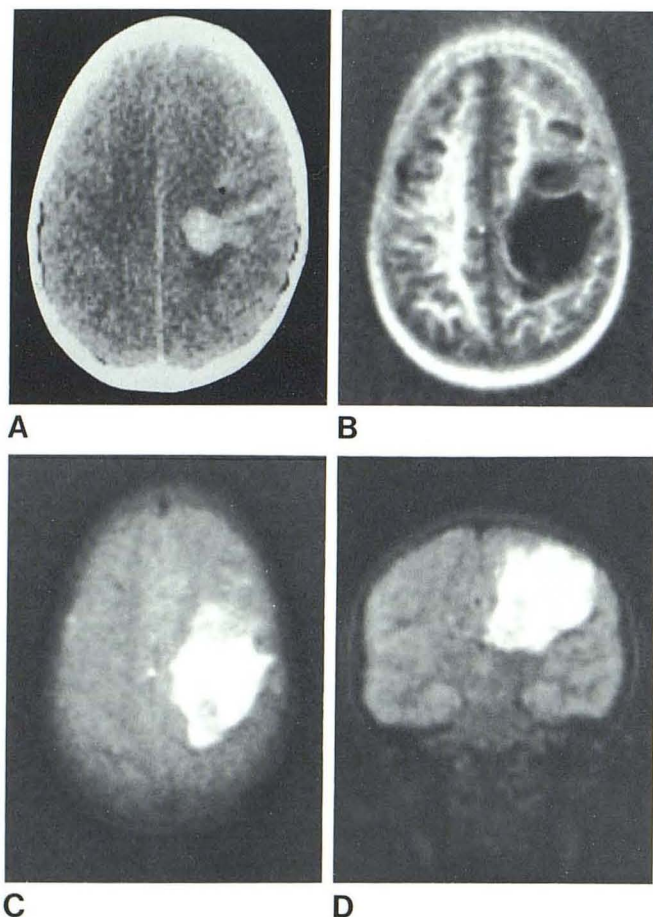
Fibrosarcoma. A, Contrast-enhanced CT scan. B, IR<sub>1400/400</sub> NMR scan. Mass displays long T<sub>1</sub> and internal structure. Transverse (C) and coronal (D) SE<sub>1160/80</sub> NMR scans show extensive surrounding edema.
